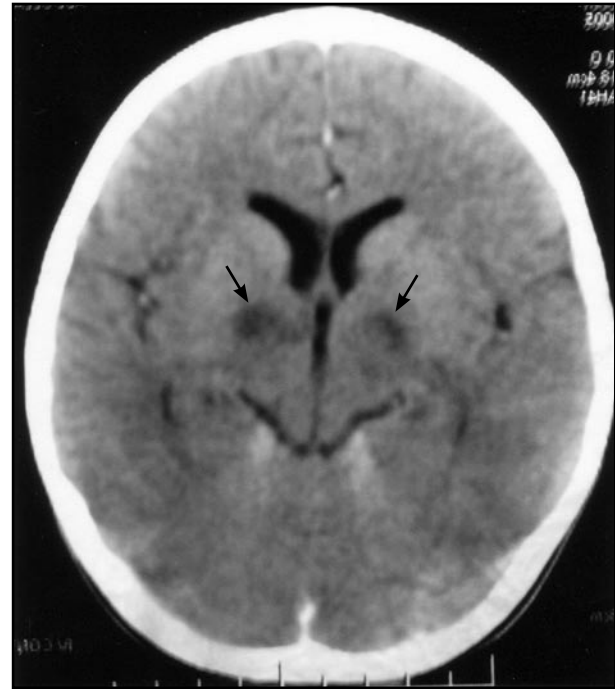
Contrast-enhanced CT brain shows non-enhancing low attenuation areas in thalami and basal ganglia bilaterally
